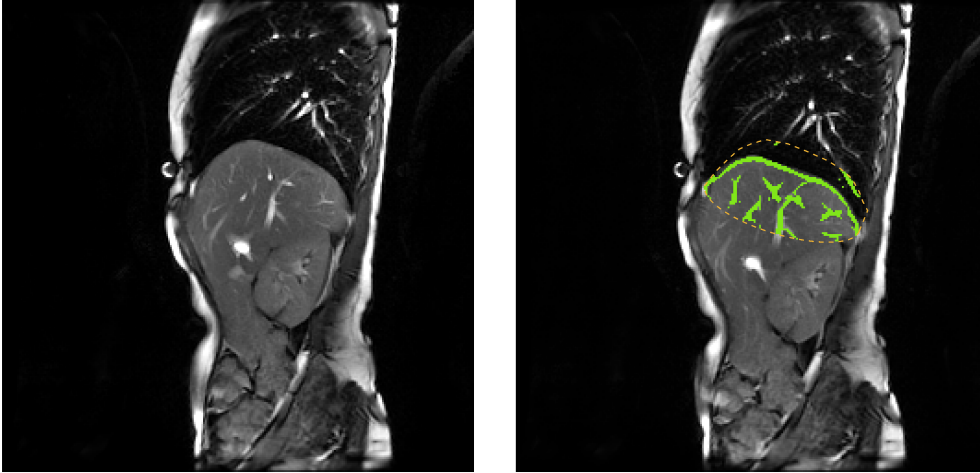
An MRI image of the diaphragm (on the left), the corresponding vessels (on the right, green coloured) and the ROI (the dashed curve).
